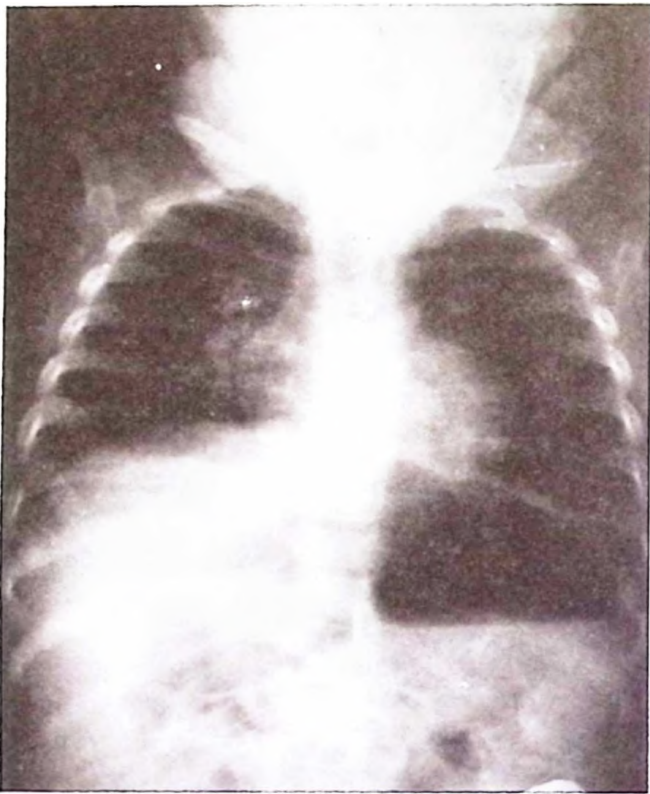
Configuration of the distended stomach and double superimposed air-fluid levels suggestive of upside down stomach on plain erect X-ray consistent with organoaxial gastric volvulus.
